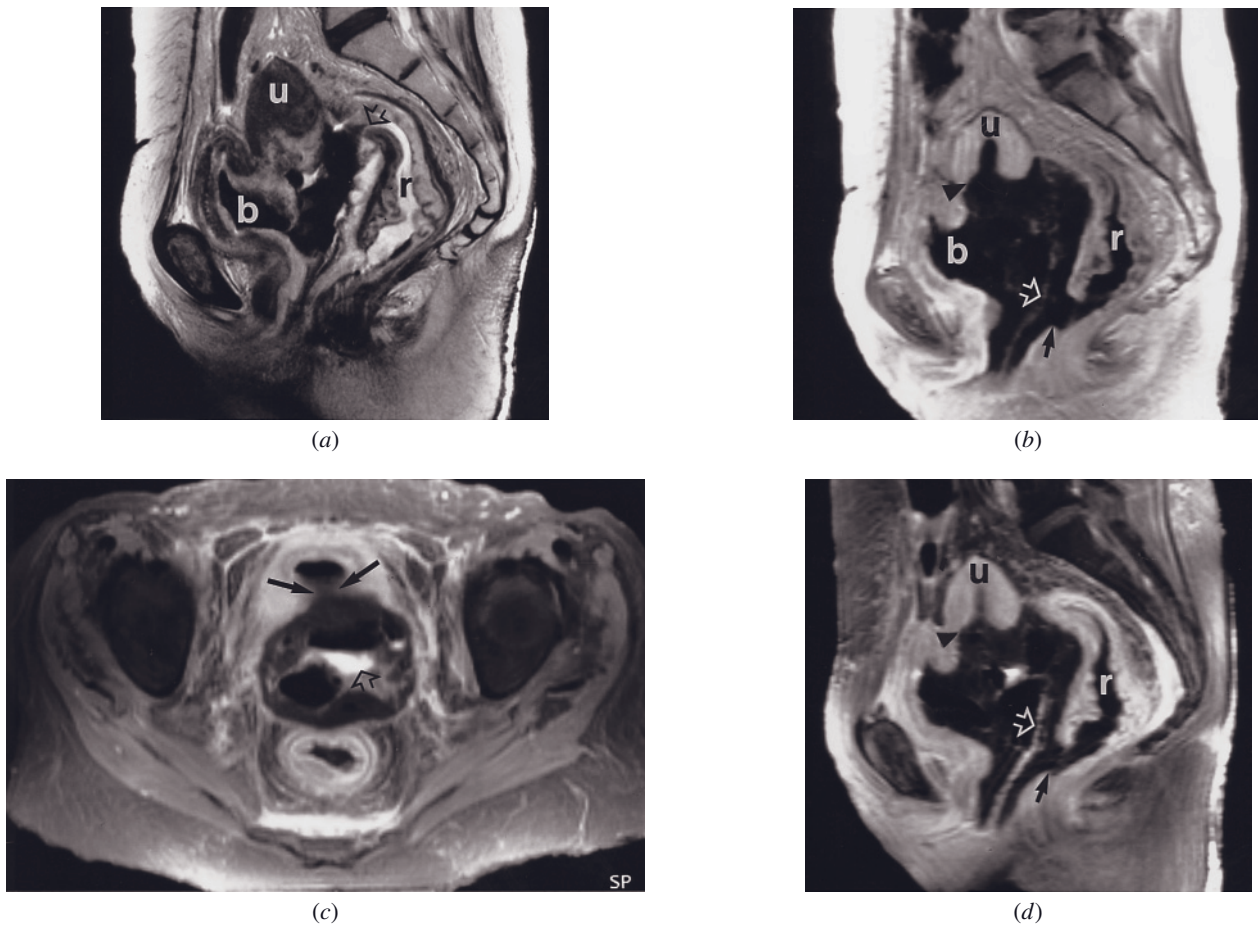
Pelvic abscess and fistulas. Sagittal T2-weighted echo-train spin-echo (a), sagittal gadolinium-enhanced T1-weighted SGE (b) and axial (c) and sagittal (d) gadolinium-enhanced T1-weighted fat-suppressed spin-echo images in a patient with cervical cancer who had undergone high-dose radiation therapy. Tumor necrosis, fistula, and abscess formation are not uncommon complications of radiation therapy. A large pelvic cavity is present with communication between bladder, uterus, and rectum, which is clearly defined on the sagittal plane images (a, b, d). The rectal wall is substantially thickened, and submucosal edema is well shown as high signal intensity on the T2-weighted image (a). The signal-void regions in the abscess cavity represent air associated with the superior and low inferior rectal fistulas (open arrow, a and solid arrow, d, respectively) and superimposed infection. There is wide communication of the abscess cavity with the bladder. After intravenous gadolinium administration, high-signal-intensity contrast (open arrow, c) exits the bladder through the large fistula (black arrows, c) and pools in the abscess. Portions of the uterine corpus and cervix have undergone necrosis; the uterine fundus remains. The posterior wall of the cervix and vagina (open arrow, b, d) is best shown on the sagittal gadolinium-enhanced T1-weighted fat-suppressed spin-echo image. r, Rectum; u, uterine fundus; b, bladder.
